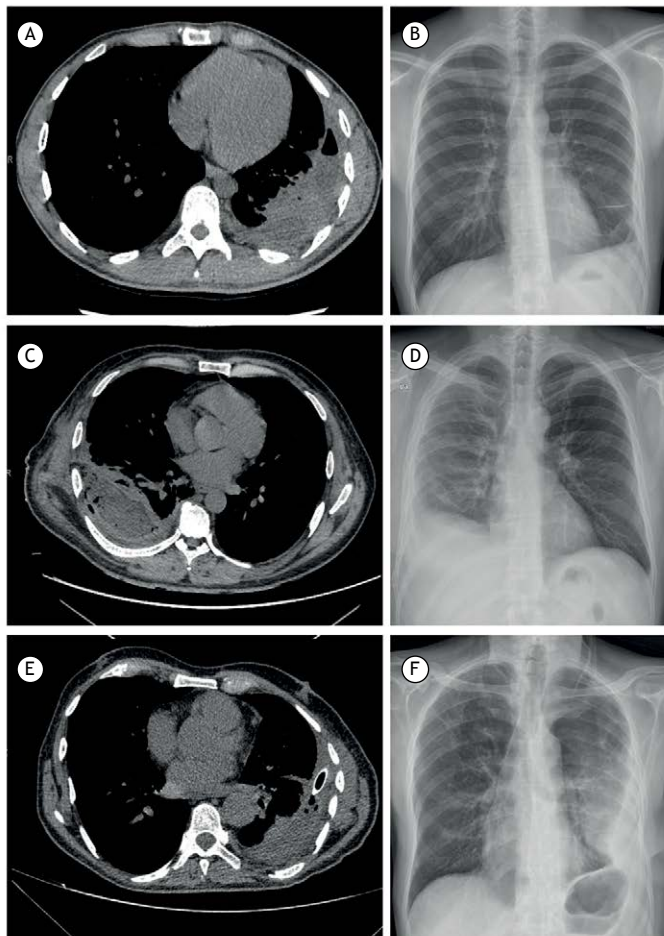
Preoperative chest CT scans and postoperative chest X-rays of cases 1 (in A and B), 2 (in C and D), and 3 (in E and F), respectively.
